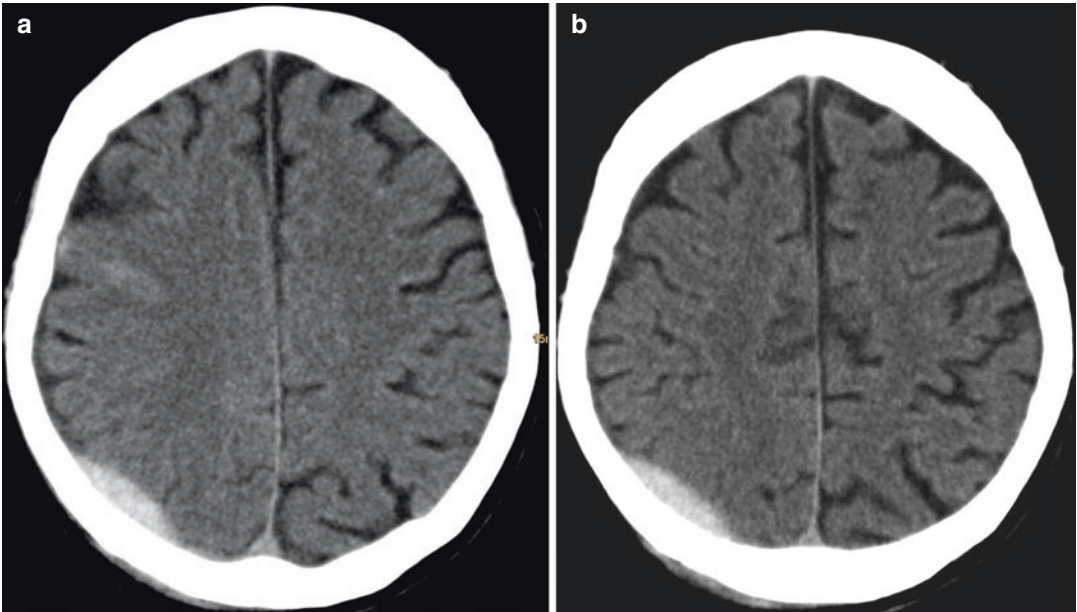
(a, b) CT scan. Epidural hematoma: presence of a well-defined biconvex, hyperdense, extra-axial collection in the right parietal region
